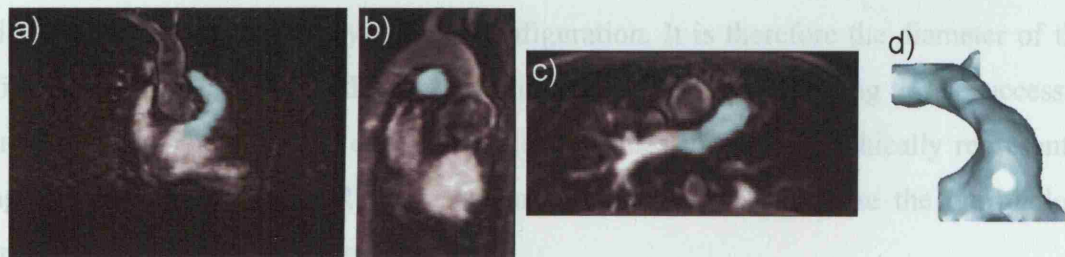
Two-dimensional MR images of the heart in the a) coronal, b) sagittal and c) axial view. The cyan mask represents the selected region of interest, the RVOT; d) Mimics 3D volume render of the selected RVOT.
